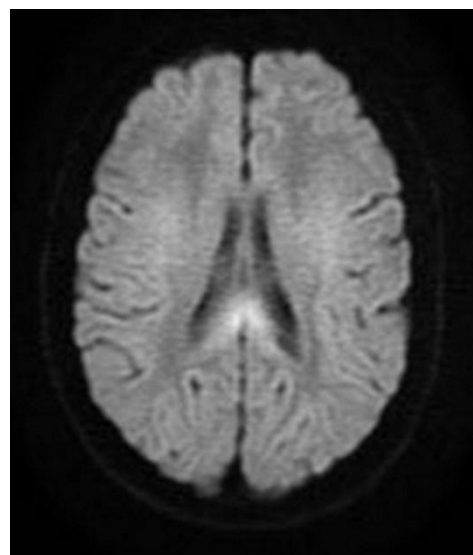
FLAIR MRI sequence showing hyper-intensity over the splenium, the corona radiata and the basal ganglia, with mild diffuse brain edema.
